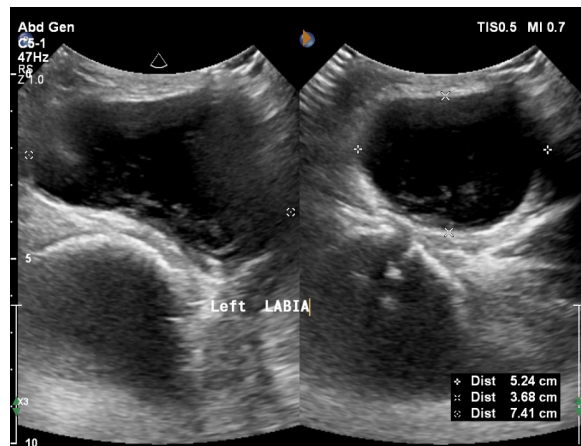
Left Labia Ultrasound
